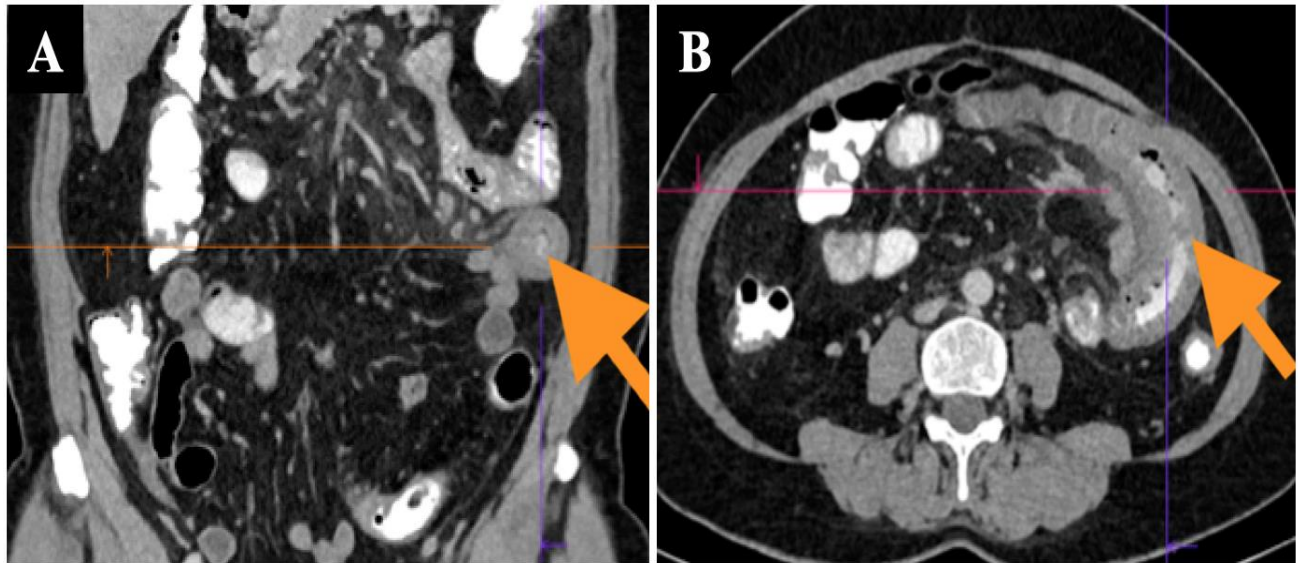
Whole abdomen CT scan with triple contrast showing persistent circumferential enhancing mucosal wall thickening in the distal jejunum (A and B, orange arrow) with associated mesenteric lymphadenopathies and mesenteric reactive changes
